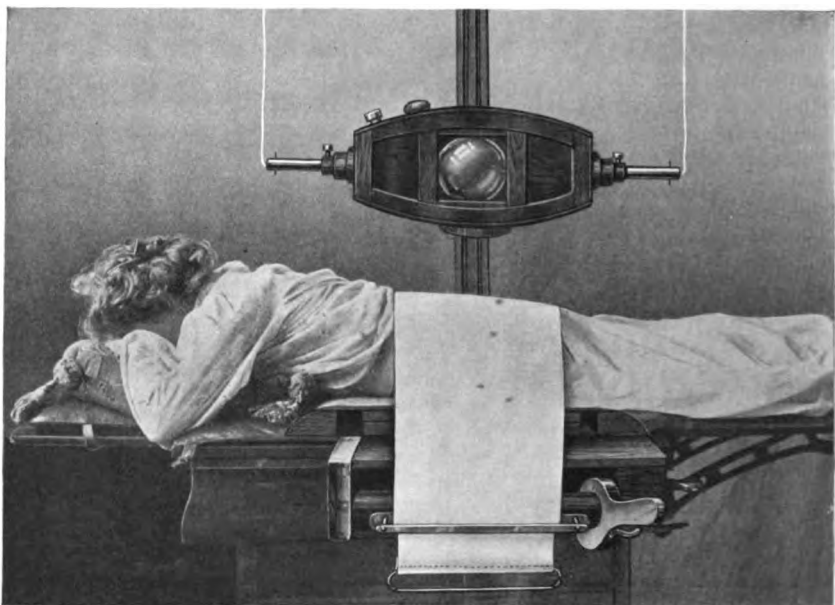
Radiography of hip-joint with a compression band and the author's plate tunnel, in which the plate may be placed and changed for stereoscopic pictures without moving the patient (page 956). The author's contact diaphragm should be used in contact with the x-ray tube.
